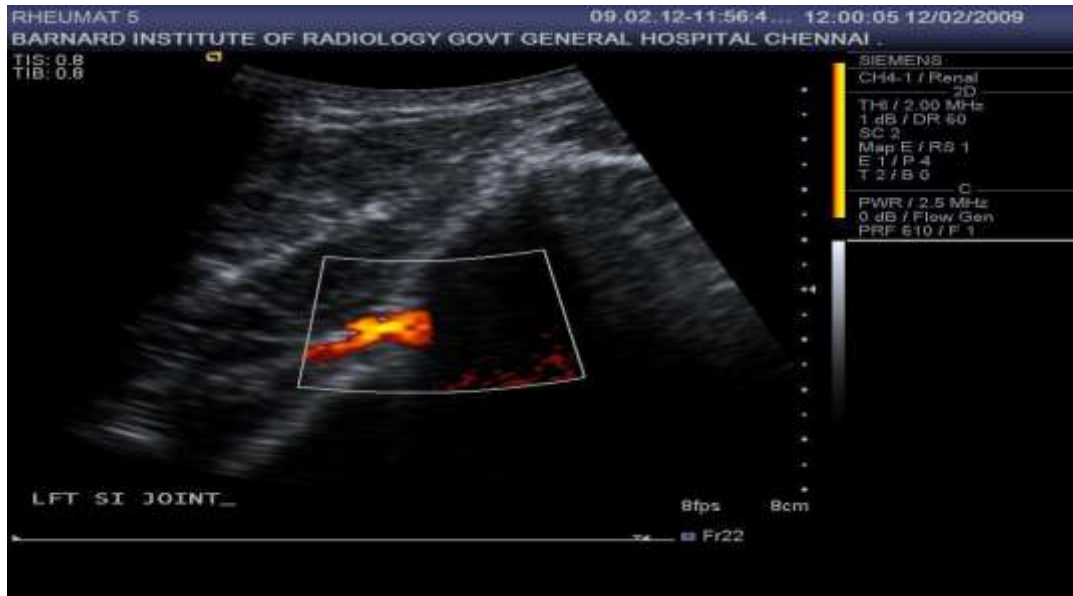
Lt. SIJ showing joint space widening, echogenic iliac cartilage and Doppler flow
